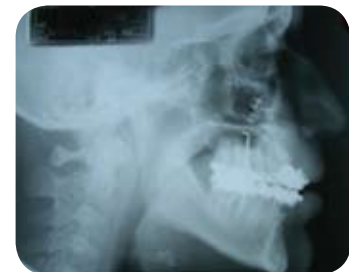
Postorthognathic surgery lateral cephalometric X-ray. Shows correction of maxillary posterior vertical hyperplasia, apertognathia, lip incompetence, and mentalis habit. Notice plate and screw fixation in superior maxilla used for the procedure.
